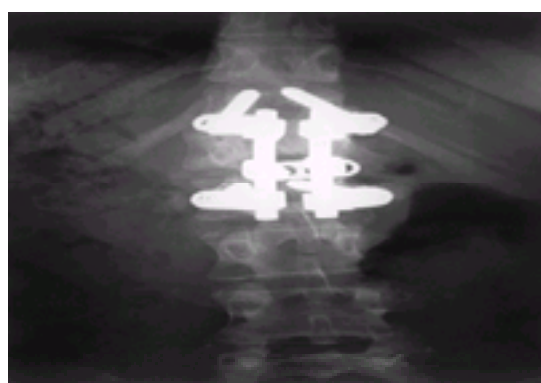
Radiograph of short-segment stabilization posteriorly for T12, L1 Chance fracture.
